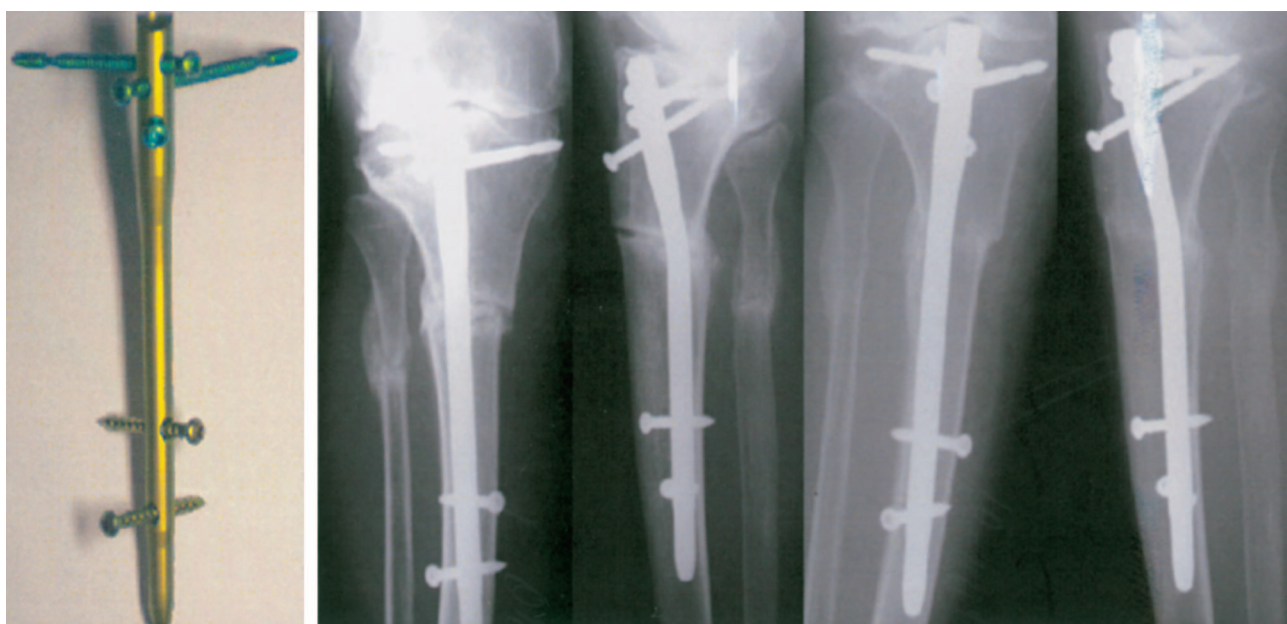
A: Proximal Tibial Nail® (PTN®, Synthes®); B: Postoperative a.p. and lateral x-rays demonstrate unreamed intramedullary nailing; C: A.p. and lateral radiographs at the time of bony union show an anatomical alignment.
